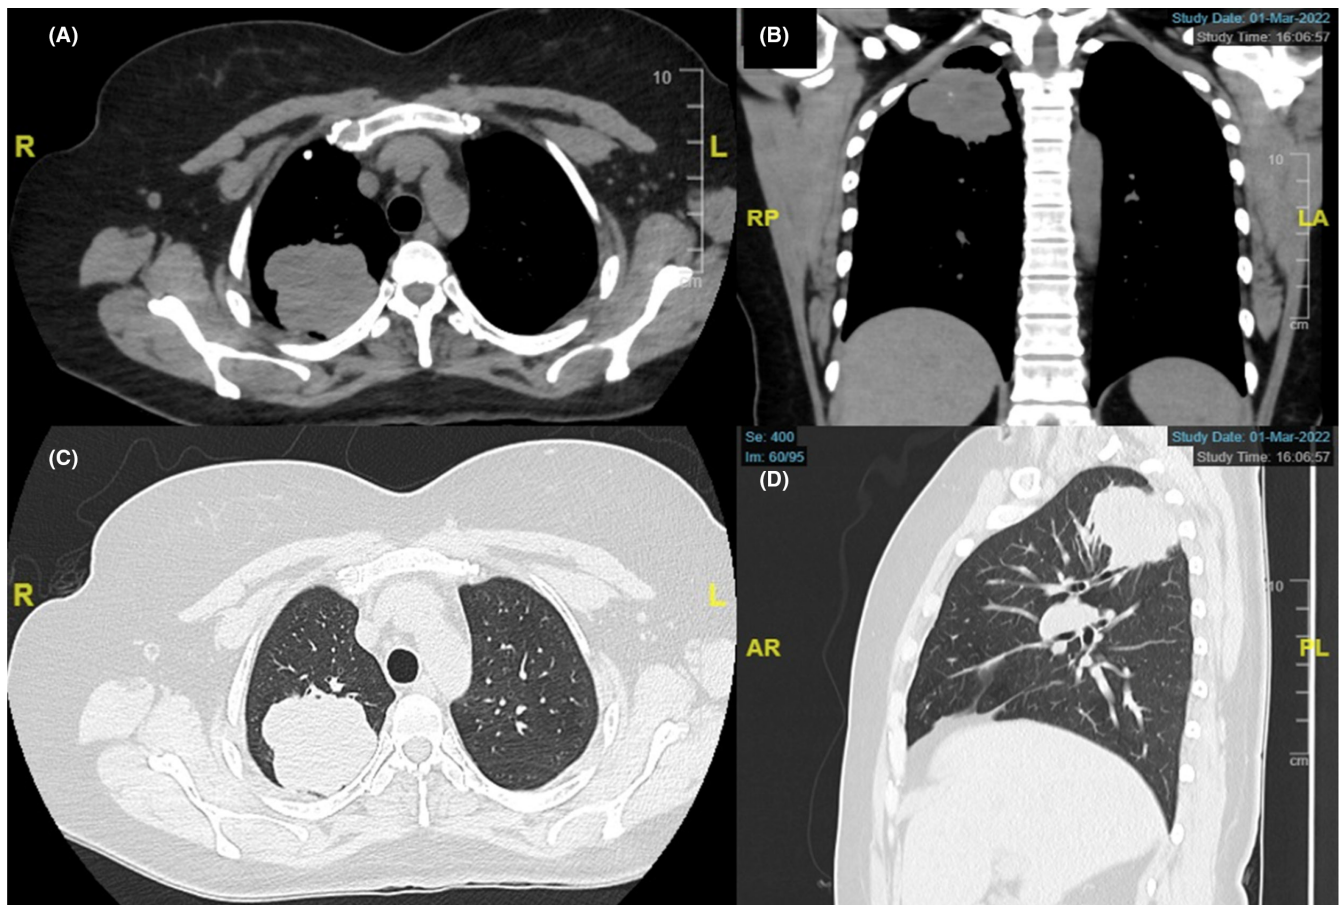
Chest CT: (A, C) axial view, (B) coronal view, (D) sagittal view; revealing an oval well-circumscribed mass projected at the right lung apex.
